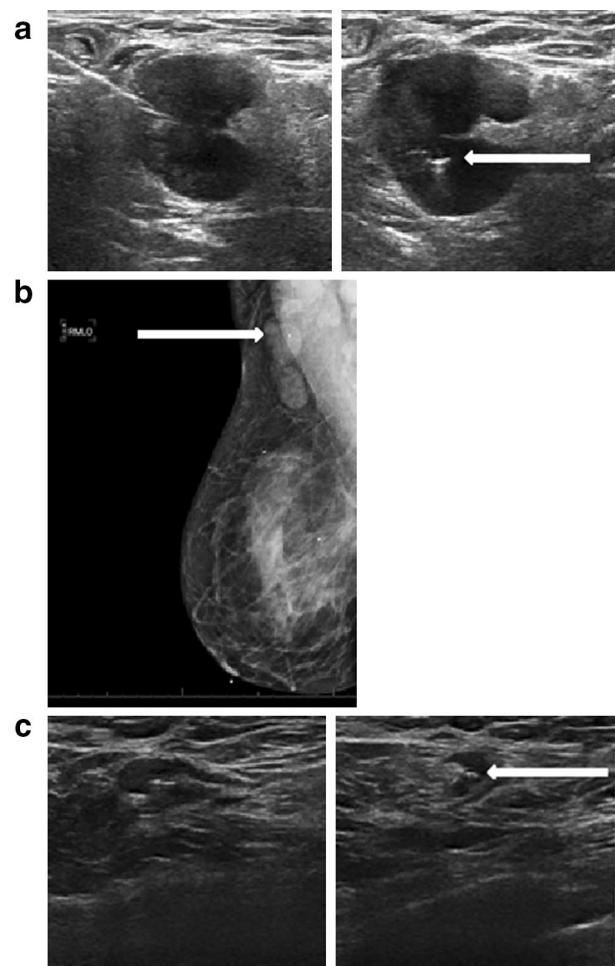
Axillary ultrasound of a patient with a right multifocal invasive ductal carcinoma and ipsilateral axillary lymphadenopathy at presentation and after neoadjuvant chemotherapy; a abnormal-appearing axillary lymph node measuring $2.6 \times 2.3 \times 2.1 \text{ cm}^3$, b fine-needle aspiration and placement of marker clip into suspicious node, c mammogram confirming clip in axillary node and clips in right breast marking the multifocal breast cancer, d interval response to therapy in the clipped node measuring $1.8 \times 0.6 \times 0.5 \text{ cm}^3$
